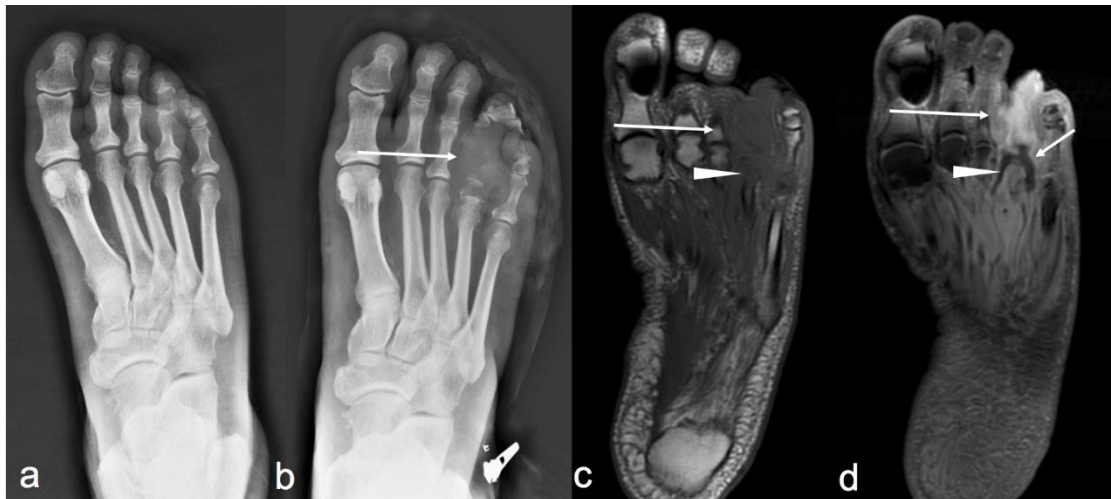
62-year-old man with 16-years history of diabetes. (a) Anteroposterior view of the foot does not show bony abnormalities. (b) Corresponding anteroposterior view obtained 21 days later shows extensive bone destruction of the fourth proximal and intermediate phalanx with associated soft tissue thickening (arrow). (c) Axial T1-weighted and (d) axial post-contrast T1-weighted fat-suppressed MR images confirm phalangeal destruction (arrow in c, and d) extending to adjacent metatarsal head with decreased signal intensity (arrowhead in c) and post-contrast enhancement (arrowhead in d). Note also an adjacent soft tissue abscess with peripheral post-contrast rim enhancement (small arrow in d).
